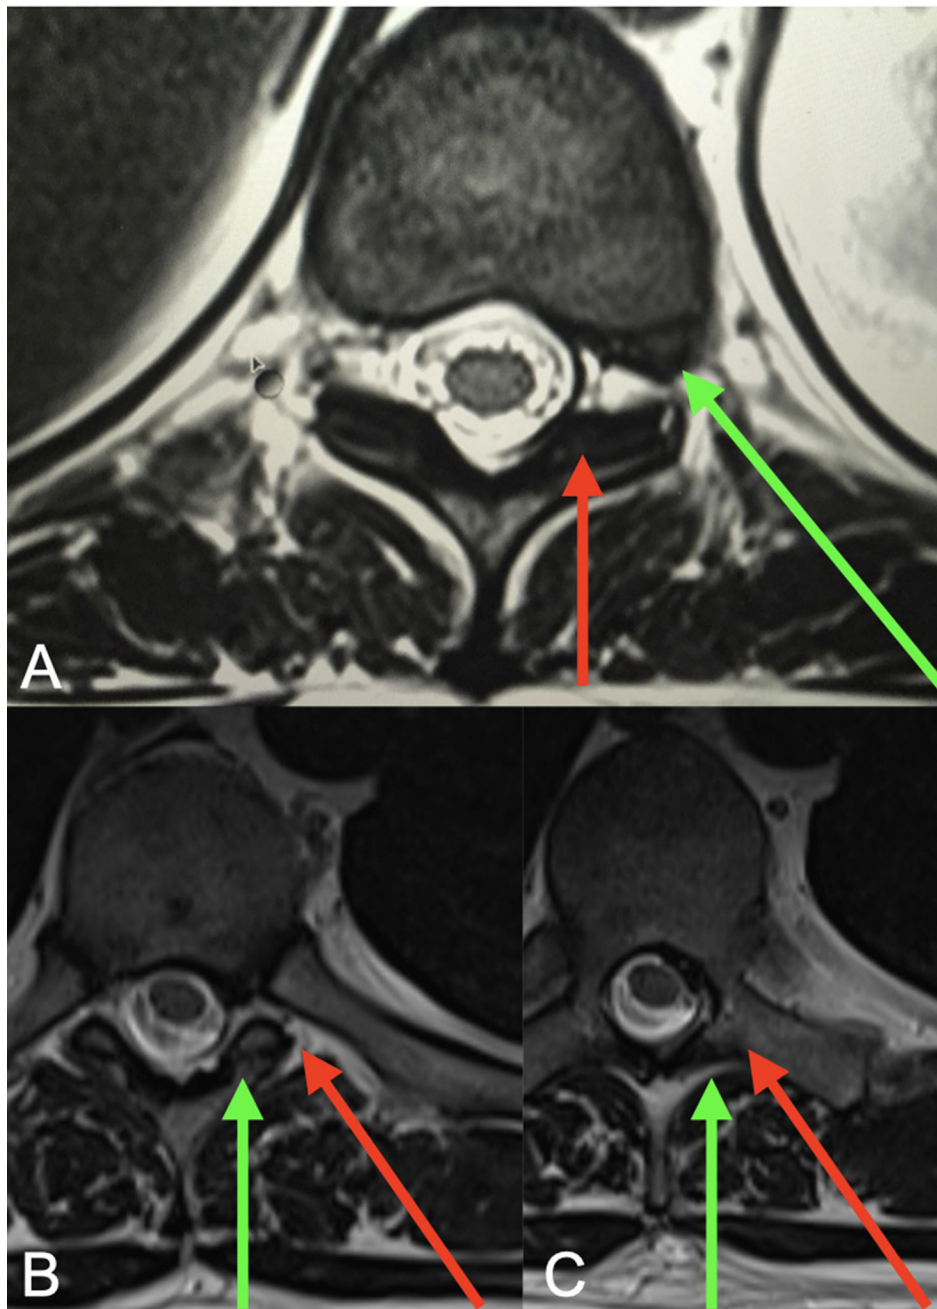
(A) Patient 1 axial magnetic resonance image (MRI) showing a T10-T11 foramina disc herniation; the green arrow shows the selected transforaminal approach, which is a straight forward direction to the disease, avoiding bone resection. (B and C) Patient 2 axial MRI showing a T7-T8 paramedian disc herniation; the green arrow shows the selected interlaminar approach, the need of medial facetectomy is more adequate than a lateral facetectomy that would be needed in a transforaminal approach (red arrow), because it allows navigation inside the spinal canal to access the migrated material, sparing the pedicle.
